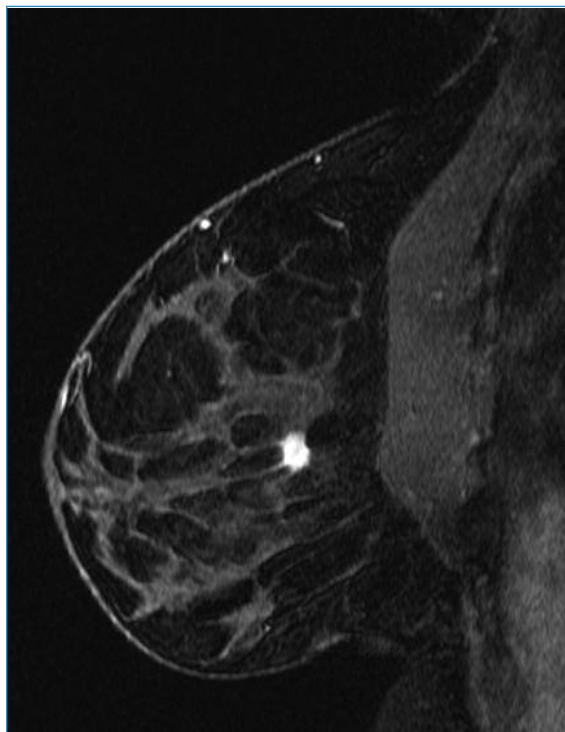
Single vertical section from a 3-dimensional high-resolution, contrast-enhanced MRI scan of the right breast. A brightly enhancing 9 mm mass, with “spiculated” margins, is visible. Subsequent MRI-guided biopsy confirmed that the mass is an invasive ductal breast carcinoma.
